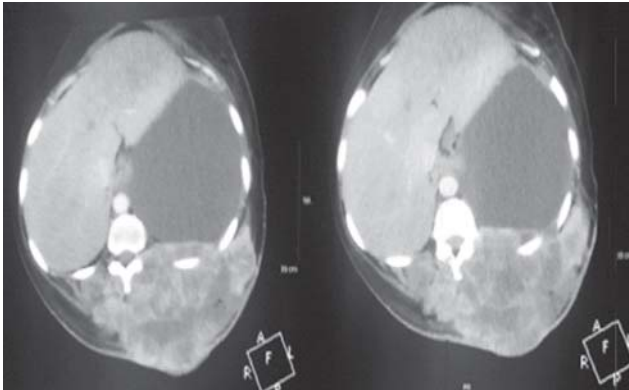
Computed tomography of chest showing tumour infiltrating into the posterior chest wall with significant fluid in pleural space.
